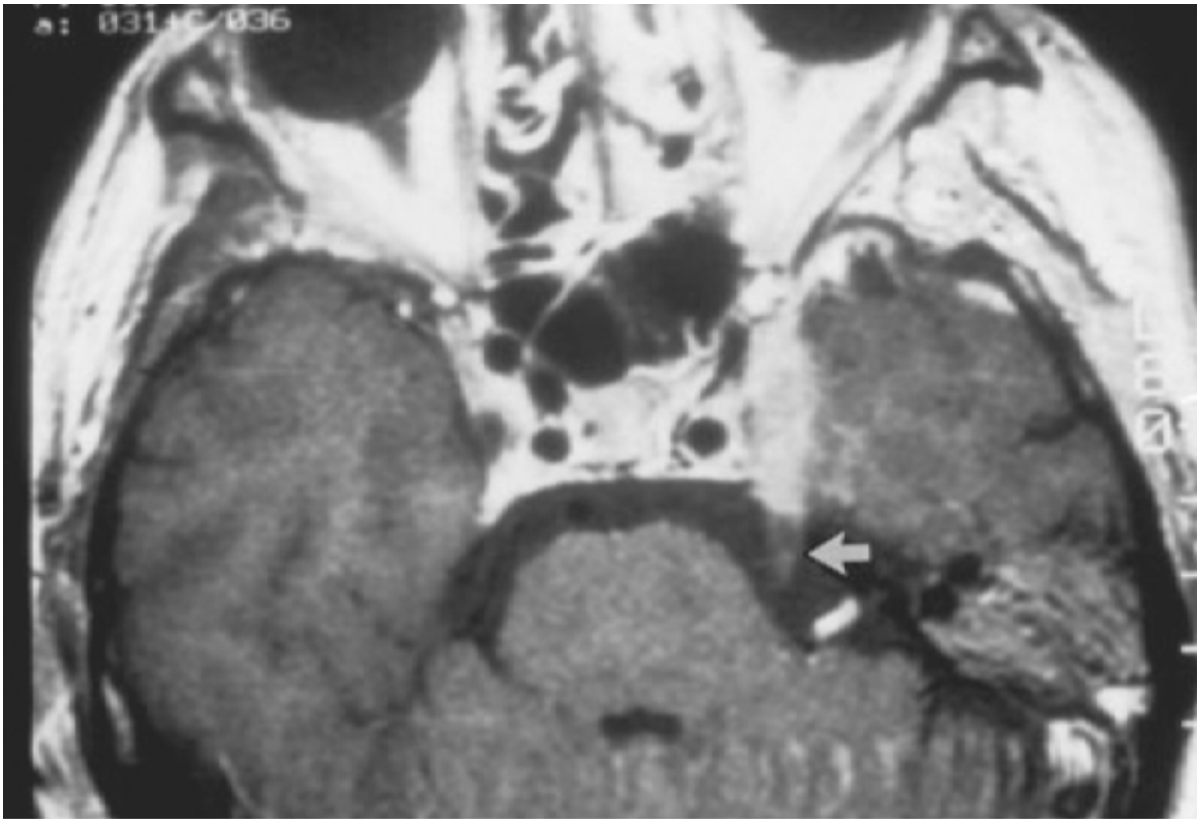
In this patient with a malignant neoplasm, magnetic resonance imaging demonstrates tumor involvement of the left cavernous sinus and perineural extension along the route of the trigeminal nerve (*arrow*).
